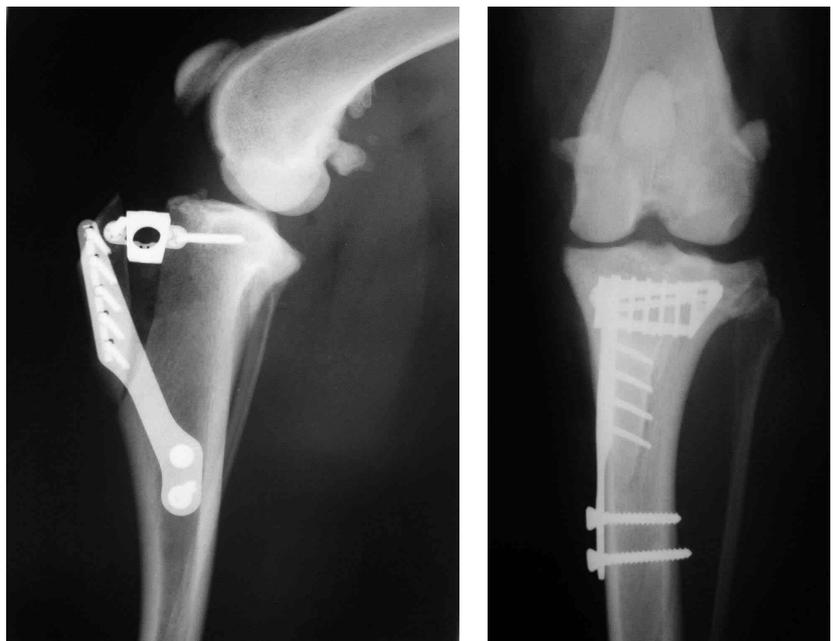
Postoperative radiographs of a 8 year old Labrador Retriever after TTA surgery.
